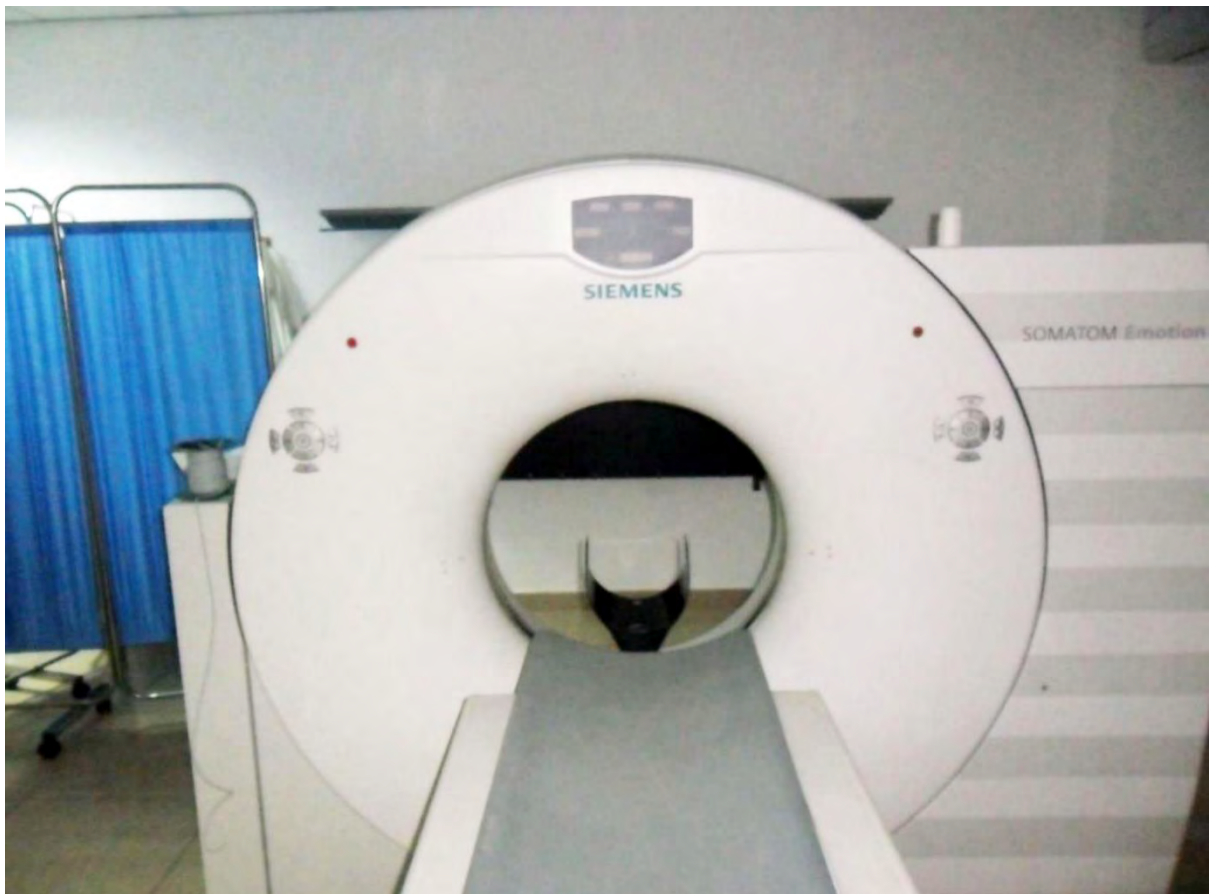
1: Picture of a 16 slice Siemens Somatom Emotion CT scanner [Field work, 2018].
